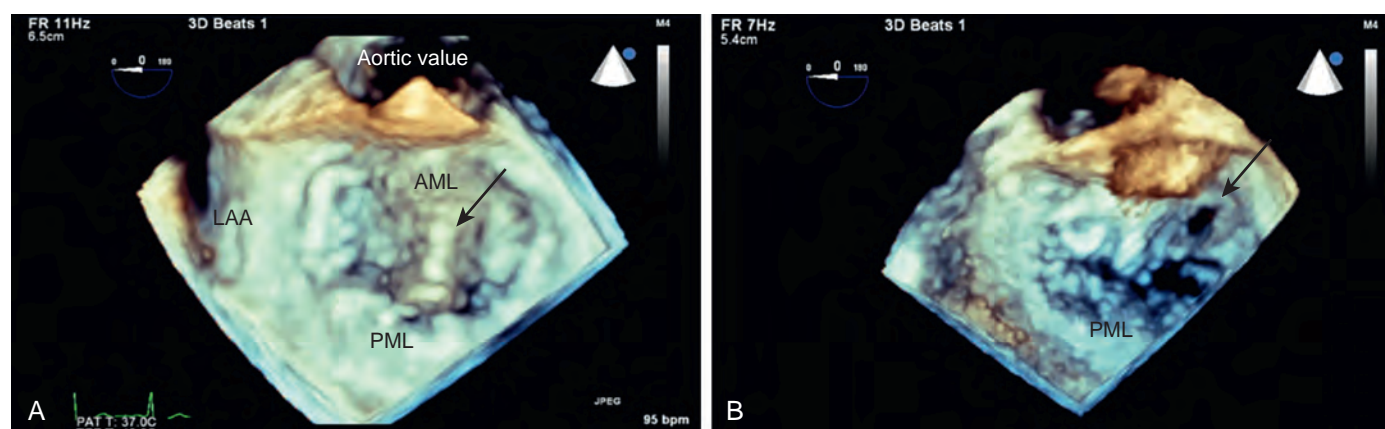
Three-dimensional transesophageal echocardiography shows the mitral valve from the left atrial aspect, with the aortic valve in the 12 o'clock position (the "surgeon's view"). A, Prolapse of the A2 scallop of the anterior mitral leaflet (arrow). B, Perforation in the A3 scallop of the anterior mitral leaflet (arrow). AML, Anterior mitral leaflet; LAA, left atrial appendage; PML, posterior mitral leaflet.
